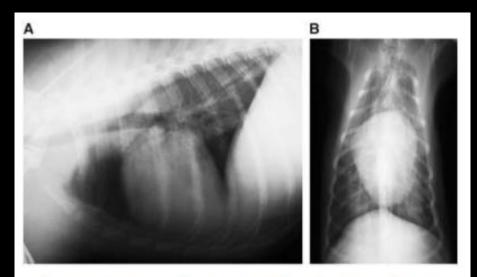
(A) Lateral and (B) dorsoventral thoracic radiographs obtained 48 h after bee-sting envenomation. There is a mild, diffuse, bilateral, linear interstitial pattern.
